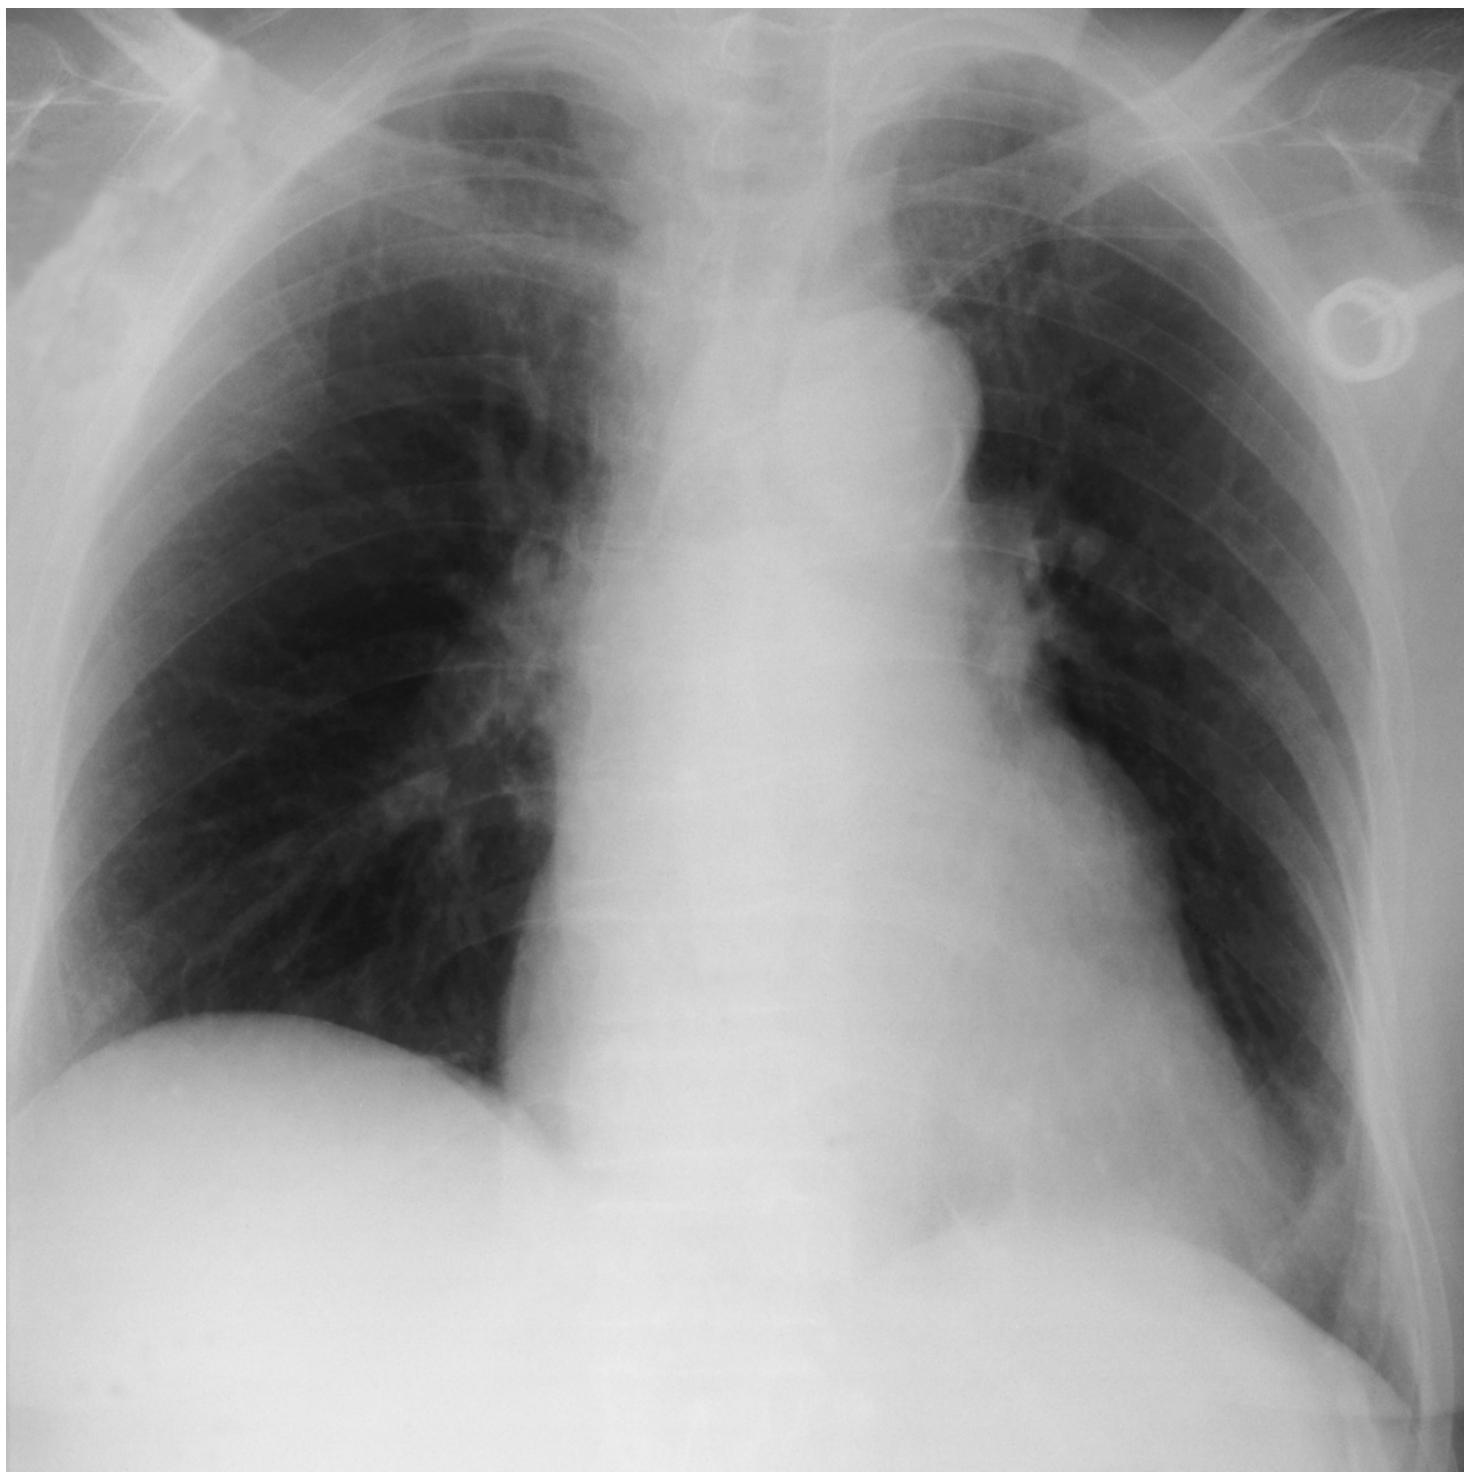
Patient with cervical carcinoma and now fever. Radiograph to verify proper position of venous port.
